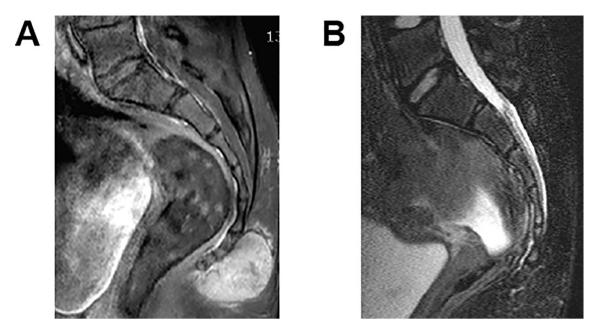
Case 1: 12-year-old female. (A) T1 weighted gadolinium-enhanced sagittal MRI revealing a contrast enhancing mass intimately related to the sacrum/coccyx, which is no longer visible following complete surgical resection (B).
